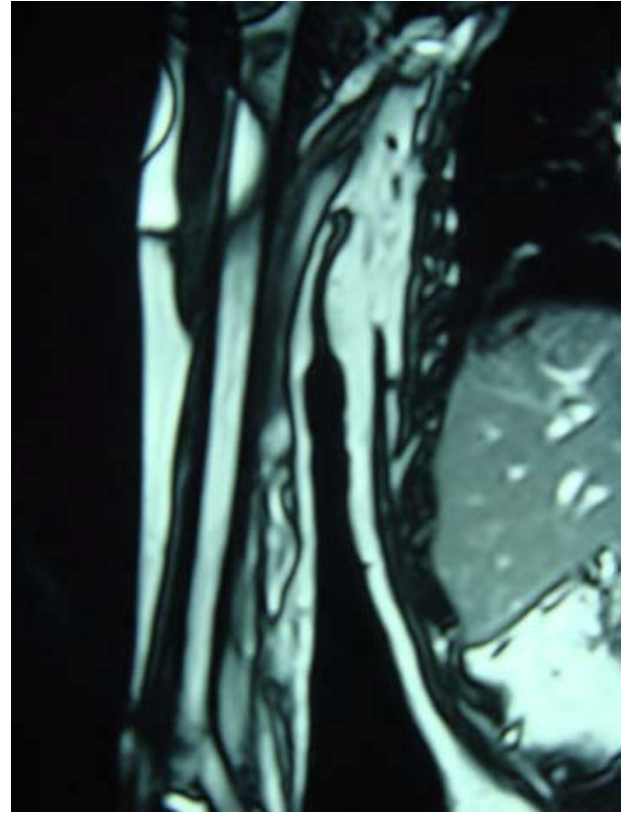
Coronal T1-weighted magnetic resonance imaging of the right arm showing the complete resolution of the hematomas.
